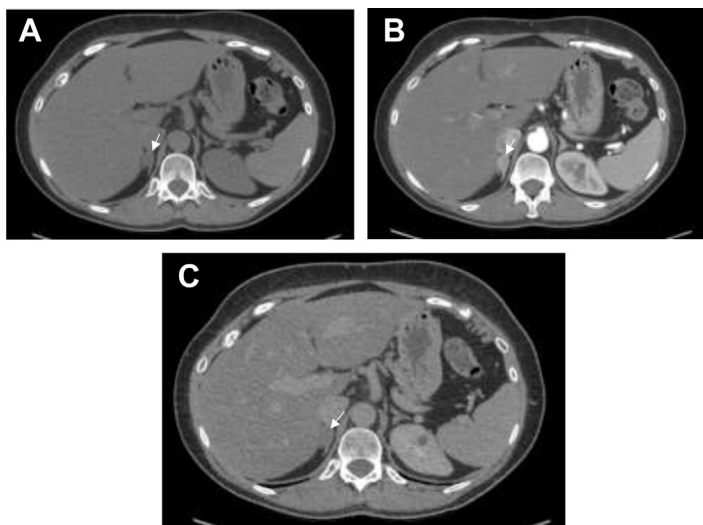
A 53-year-old woman with a 14-year history of hypertension requiring multiple medications and hypokalemia with occasional muscle weakness and fatigue was referred to the endocrinology clinic while being treated for her breast cancer. Primary hyperaldosteronism was suspected. Axial unenhanced CT (A) demonstrates a well-circumscribed 1.5-cm oval mass involving the right adrenal gland with an attenuation of 19 HU. Contrast-enhanced CT in the portovenous phase (B) shows contrast uptake of the lesion, with attenuation of 106 HU. Delayed 15-minute axial CT (C) shows contrast washout with attenuation of 42 HU, yielding an absolute enhancement washout of 74%, characteristic of a lipid-poor adenoma (arrow).
